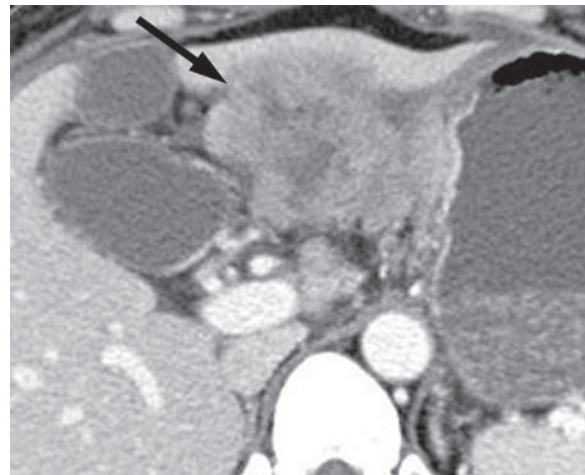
Invasion of the liver by stomach cancer in a 38-year-old woman. CT scan shows invasion of the liver by stomach cancer (arrow) via the gastrohepatic ligament.
